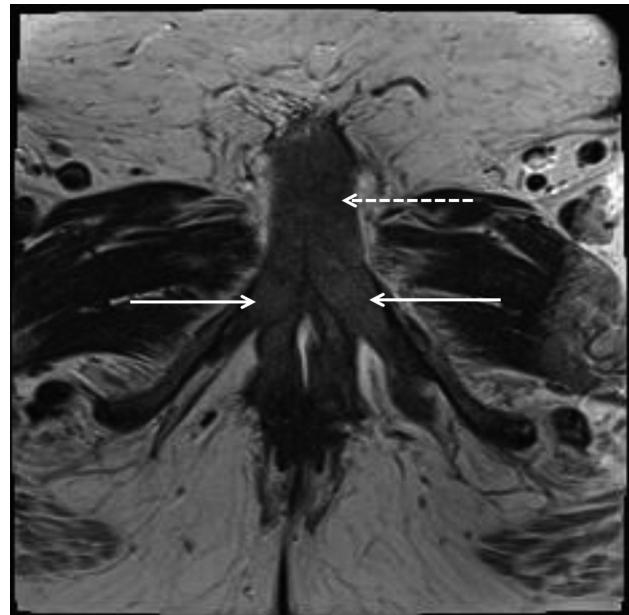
MRI (pre-op) axial T2-weighted image showing globally enlarged bilateral clitoral tissue, bulbous portion measuring  $3.5 \times 5.0$  cm. Solid arrow: expanded right and left crus of clitoris, dashed arrow: expanded clitoris.
